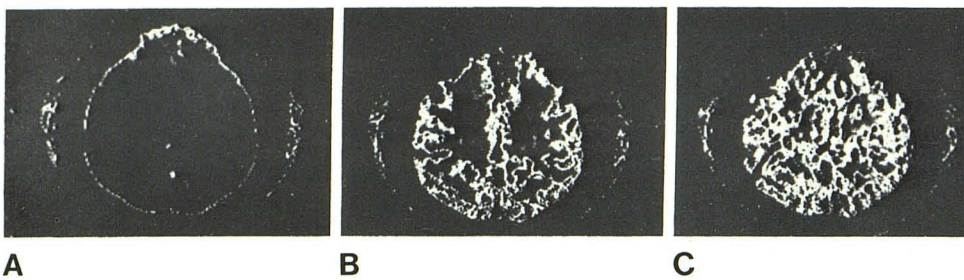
Serial CT, xenon buildup (in vivo "autoradiographic" map). CT scans before (A, baseline) and 3 (B) and 6 (C) min after start of 80% xenon inhalation at level just above bodies of lateral ventricles; measure mode photography used to accentuate visualization of brain enhancement. B, 3 min scan. Enhancement occurs primarily in gray matter. C, 6 min. Both gray and white matter are similarly enhanced.
